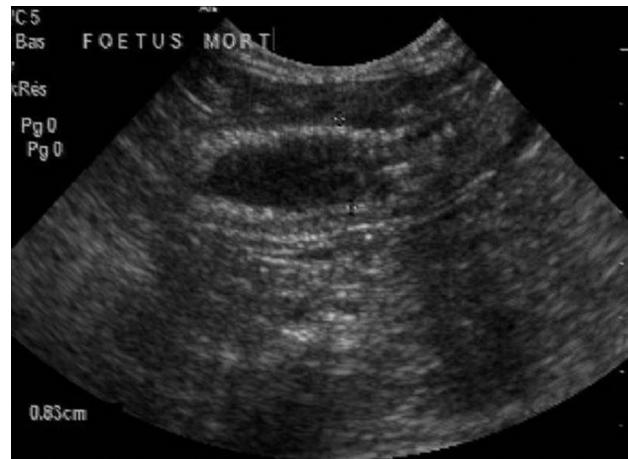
Uterine ultrasound of a one-year-old 45-day pregnant ferret showing a single fetus without heartbeat in the left uterine horn.
